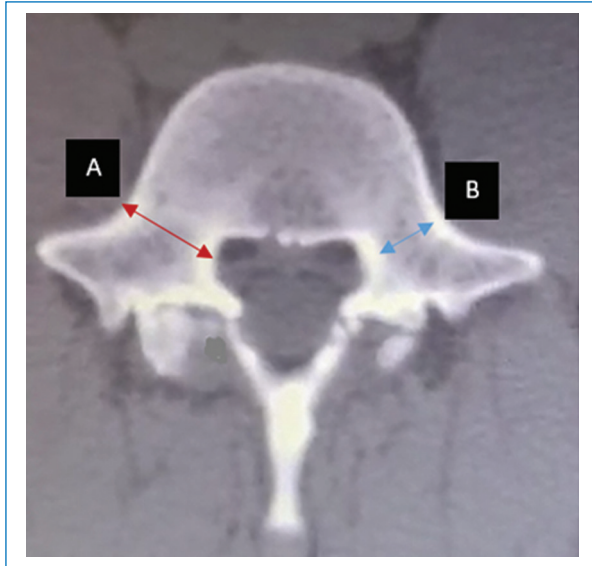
Simple computed tomography scan showing an axial cut of L5. A: external cortical width and B: internal cortical width.
